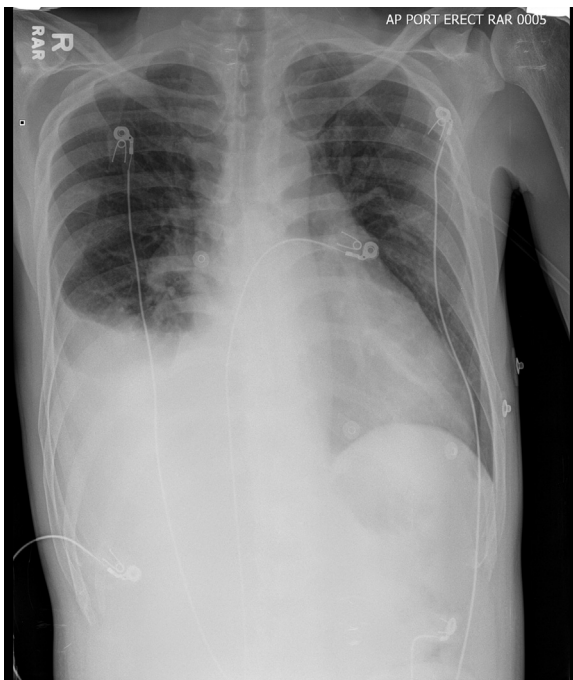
A portable chest X-ray study reveals cardiomegaly, a moderate right pleural effusion, and a slightly enlarged mediastinum.
